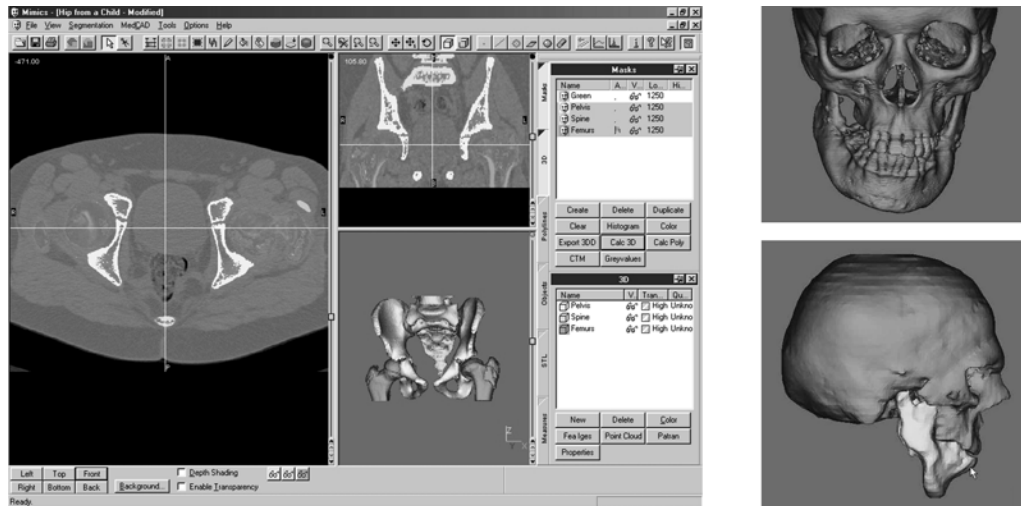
CT data processing with Mimics (Materialise NV)
